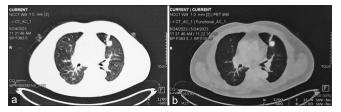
(a and b) Positron emission tomography scan showing FDG (Flurodeoxyglucose) avid cavity and nodule in the anterior segment of the left upper lobe of the lung.
